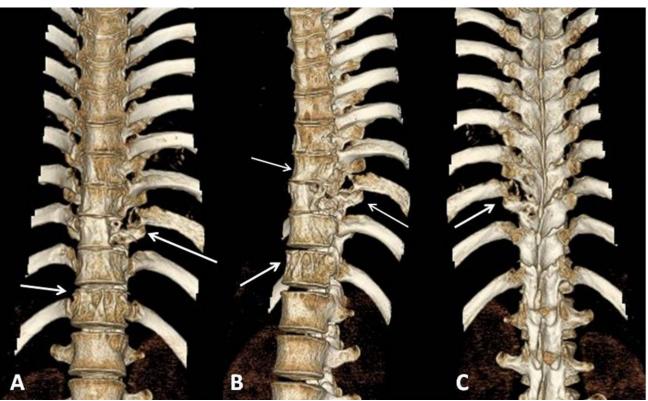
A 30 year old female with atypical spinal tuberculosis. Three dimentional (3D) reconstruction of the thoraco-lumbar spine showing the bone destruction in the lower thoracic vertebrae involving the vertebral bodies and the posterior elements (arrows). Technique: Multi detector CT scanner (64 slice), 3D reconstruction of 0.6mm slice thickness scan.
